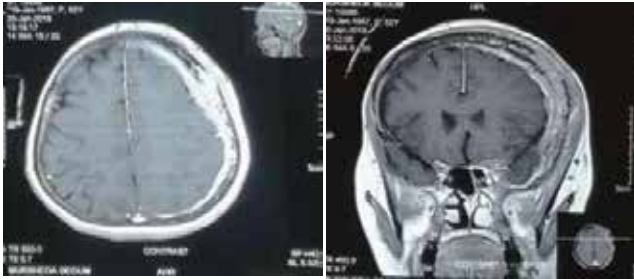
Contrast MRI of head, axial and coronal view showing a extradural, intradiploic enhancing mass lesion without intracranial extension occupying left fronto-parietal region.
